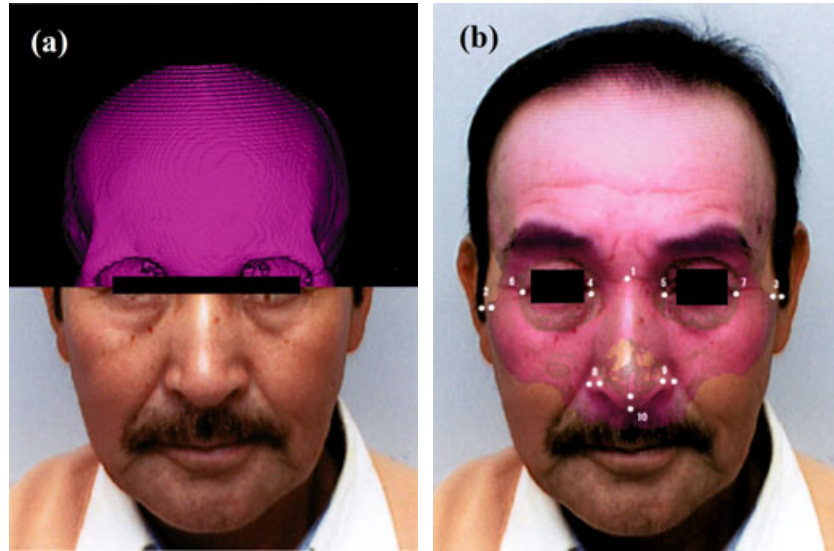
Superimposition of 3D-CT images and the antemortem picture of the victim: (a) the horizontal wiped image above the palpebral fissure, and (b) the faded image.
